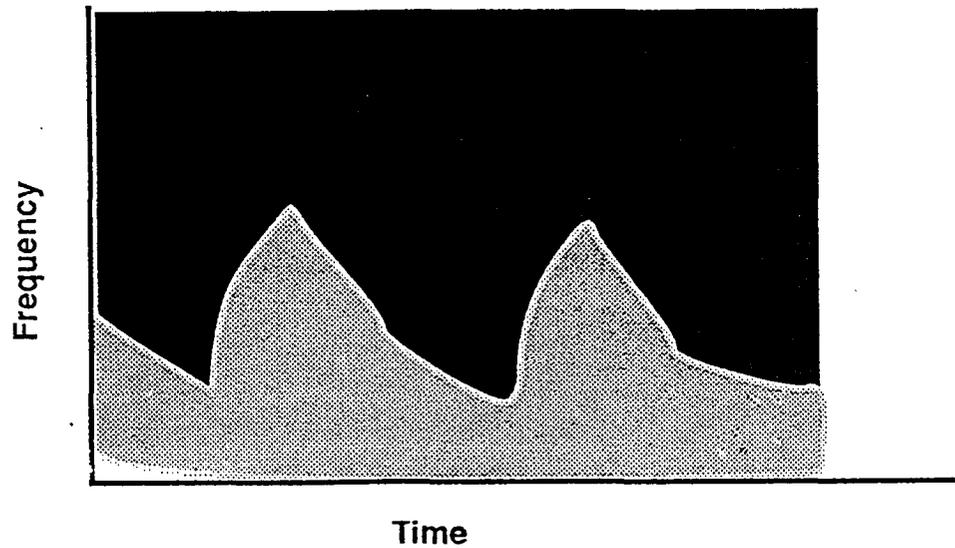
Doppler Tracing: Internal Carotid Artery
